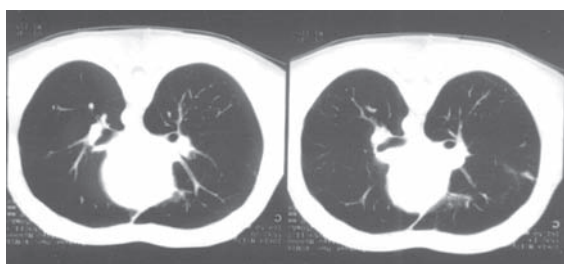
Repeated thoracic computed tomography scan done two months after the first showed complete resolution of the cavity in the middle lobe and almost complete healing of the lesion in the upper lobe of the right lung, with only a small amount of scarring. The nodular lesion in the lower lobe of the right lung had completely resolved, and the infiltration in the same lobe had regressed.
